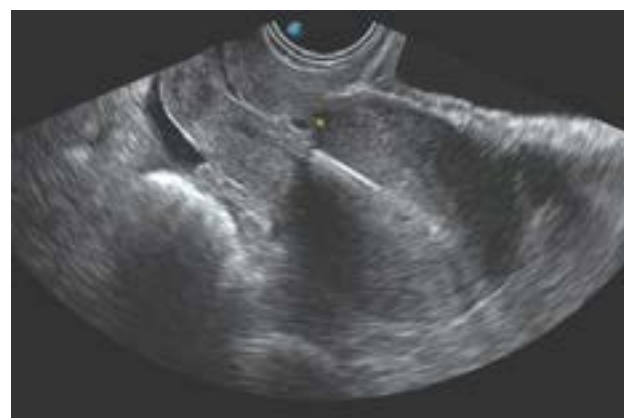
Ultrasound image shows cervix and body of uterus are in same axis as ultrasound beam, with Cesarean scar defect (a filling defect) within the myometrium of the lower uterine segment
